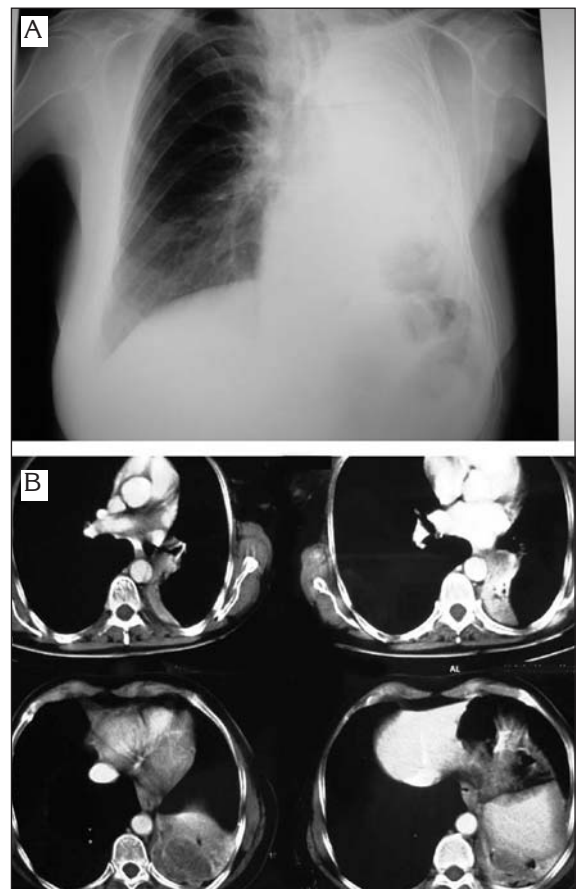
(A) Chest X-ray on shows left lung collapse, (B) earlier computed tomography scan on reveals left lower lobe collapse.
